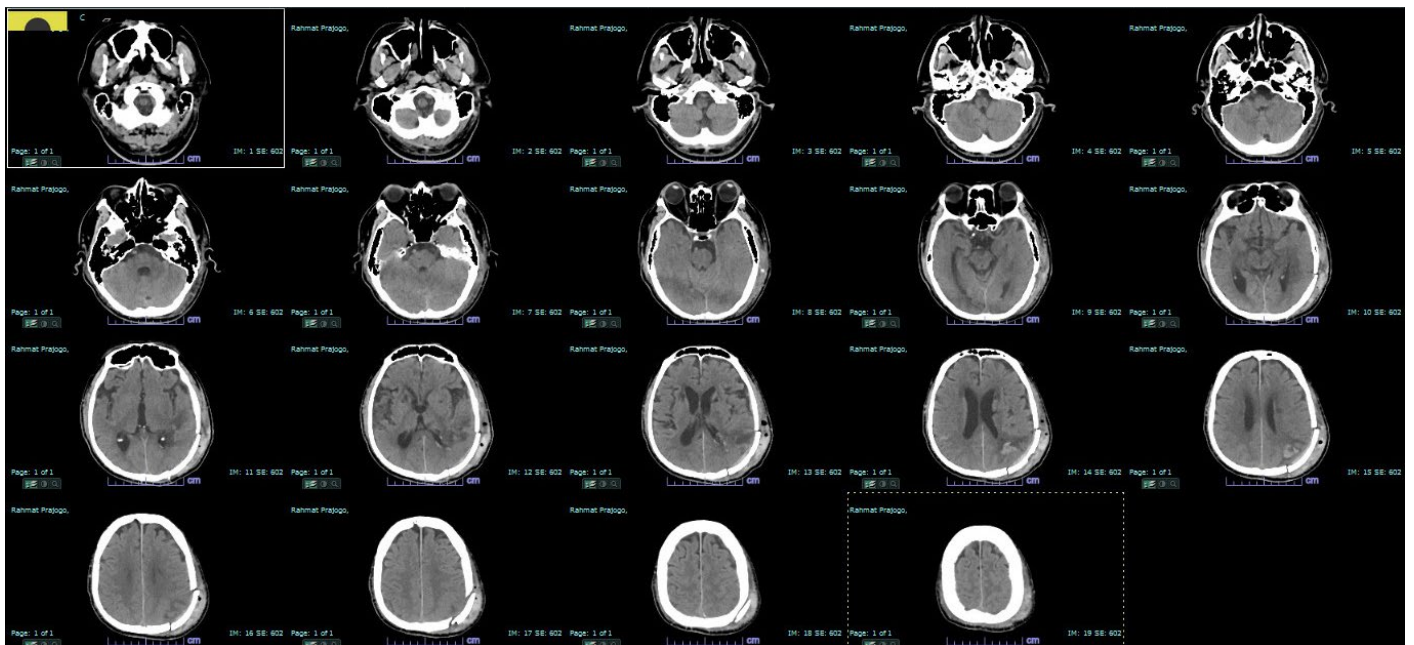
Brain CT scan 6 days post-operative, showing a decrease in intracerebral hemorrhage.
